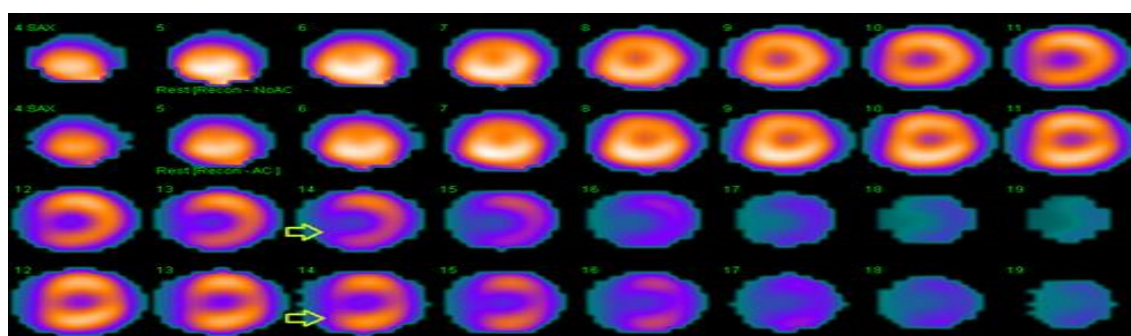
Final attenuation-corrected short-axis cardiac sections obtained with SPECT/CT at a Rest MPI of patient without AC and with AC.
